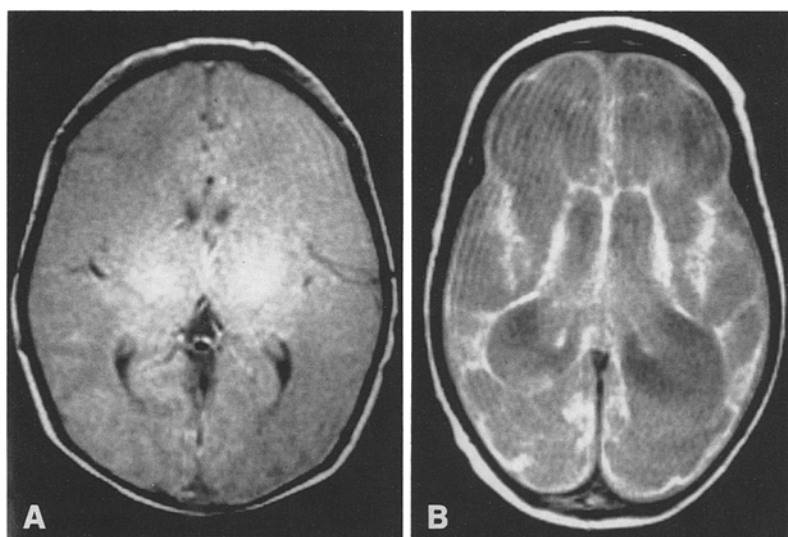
A Magnetic resonance imaging (MRI) scan performed on day 29 of life shows diffuse loss of gray-white contrast. High-intensity signal limited to basal ganglia and thalami is consistent with the presence of methemoglobin. B Follow-up MRI scan at 4 months of age shows multiple cystic cavities of end-stage multicystic encephalopathy
